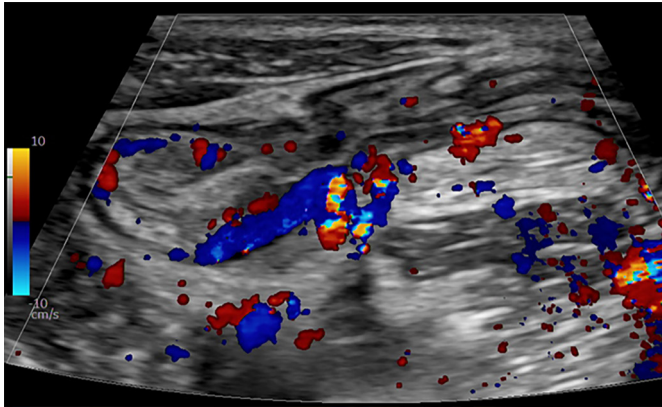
A case of active inflammation in the terminal ileum. The color Doppler signal is markedly increased, with a Limberg score of grade 3 (long stretches extending into the mesentery).
